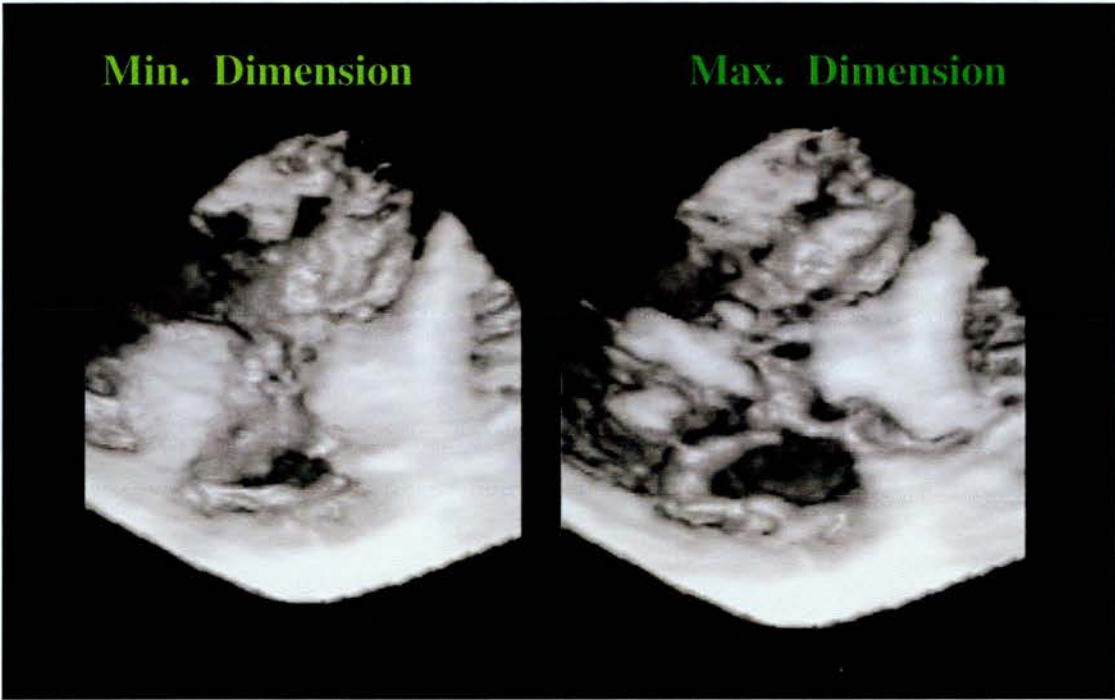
Changes in atrial septal defect dimension during a cardiac cycle as seen by three-dimensional Doppler myocardial imaging echocardiography.
